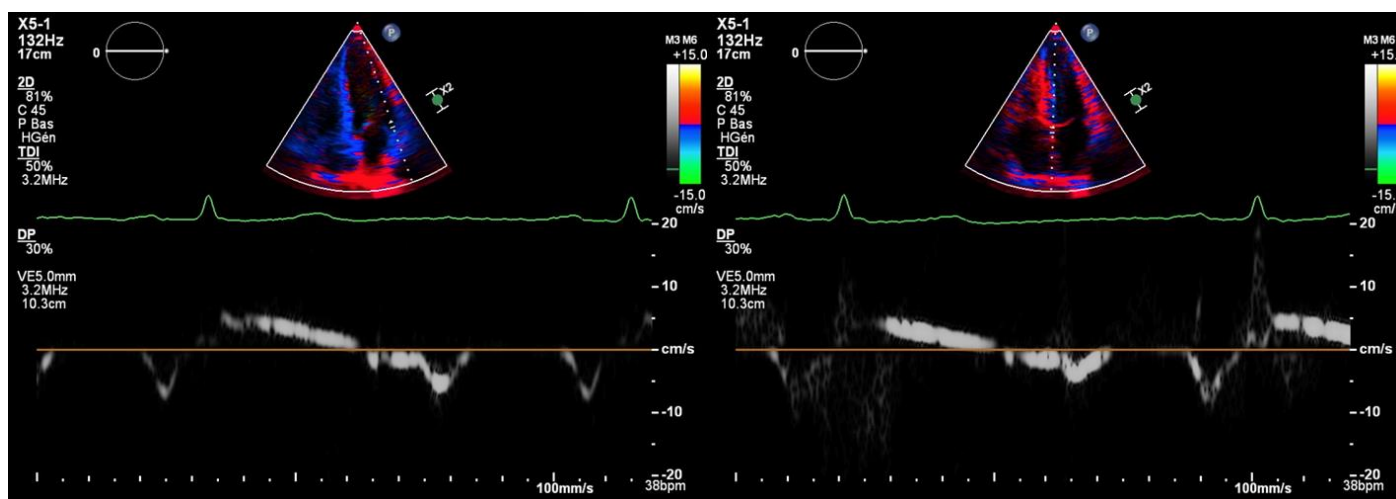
Tissue Doppler imaging at lateral and septal mitral annulus: increased S' wave duration.
